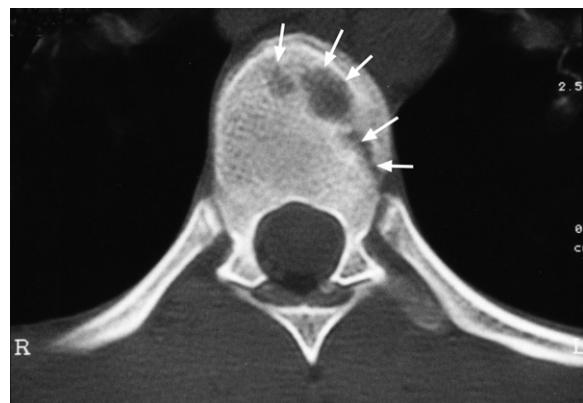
CT axial image through the T8 vertebra. Note the incomplete body union at the fracture sites (white arrows).
